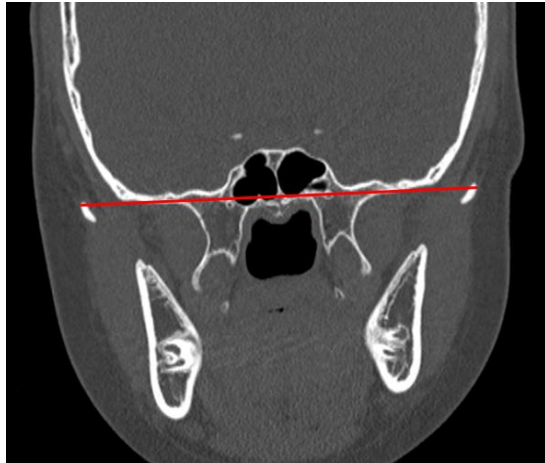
CT scan in the midfacial region displaying the Zygomatic arch distance (red) (coronal view)
